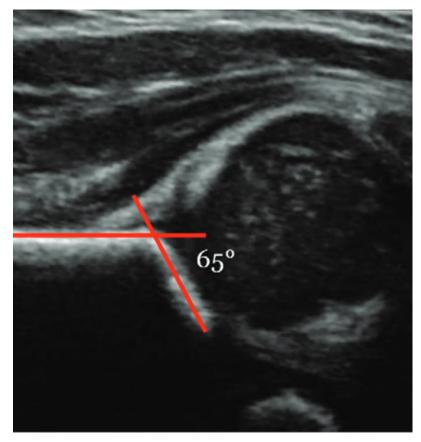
The alpha angle measurement of the hip joint from ultrasound examination (JL Jaremko, Potential for change in US Diagnosis of hip Dysplasia solely caused by changes in Probe Orientation: Patterns of Alpha-angle Variation Revealed by Using Three-dimensional US, 2014)
